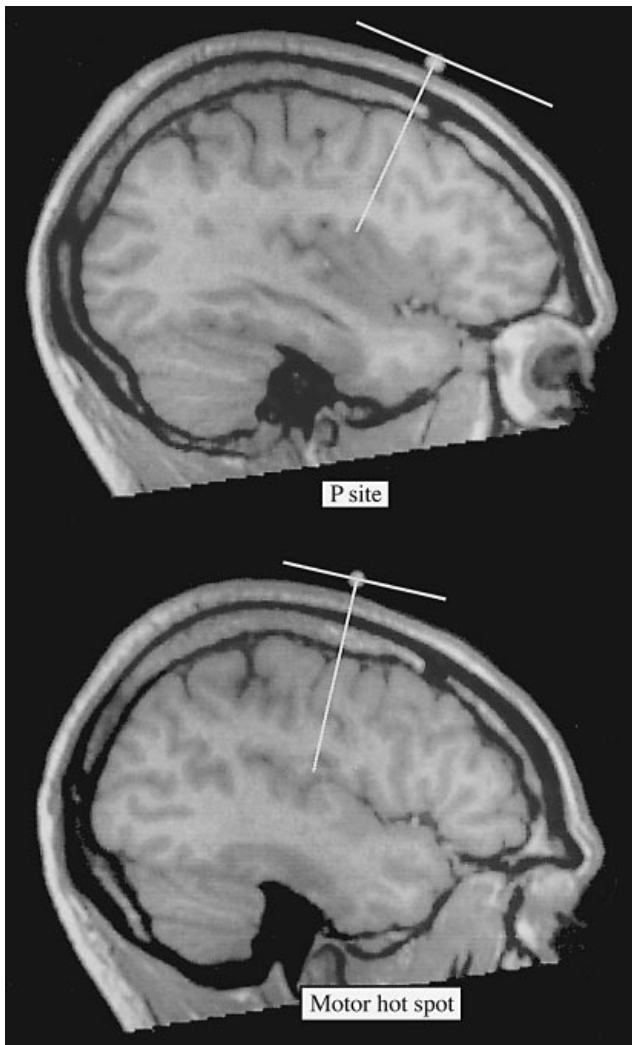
The T-bars are superimposed on one subject's MRI scan to indicate the P site (above) and hot spot site (below) of stimulation. The bars were constructed by placing a line tangential to the skull at the point of stimulation and dropping a perpendicular into the grey matter. The P site was over the superior limb of the precentral sulcus and the hot spot was over the anterior bank of the central sulcus.
